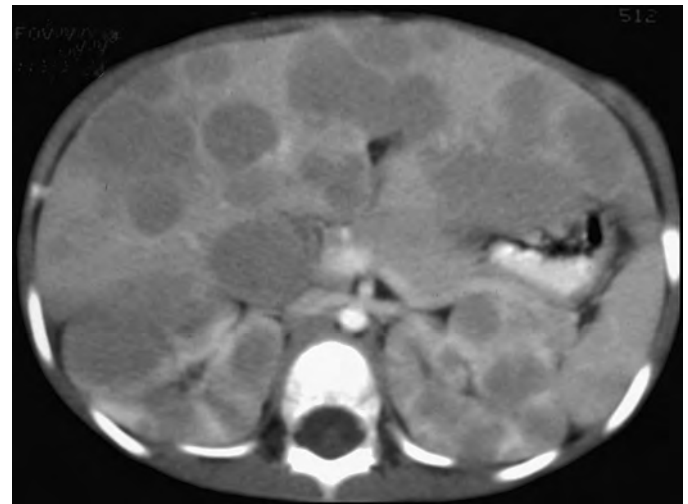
Burkitt's lymphoma. Contrast-enhanced CT of the upper abdomen reveals multiple, low-attenuation liver masses from metastatic Burkitt's lymphoma in a 6-year-old boy. Notice the multiple, low-attenuation renal lesions, which also result from metastatic Burkitt's lymphoma.
